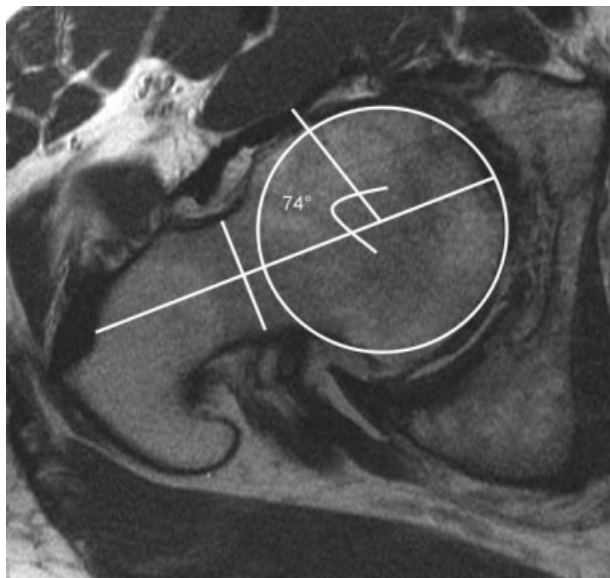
Oblique axial MR image demonstrates an enlarged alpha angle of 74 degrees (Normal alpha angle $\leq 55^\circ$). The alpha angle is defined as the angle between a line intersecting the center of the femoral head and center of the femoral neck at its narrowest point, and a second line drawn from the center of the femoral head to the point where the proliferative bone formation exceeds the radius of the femoral head.
